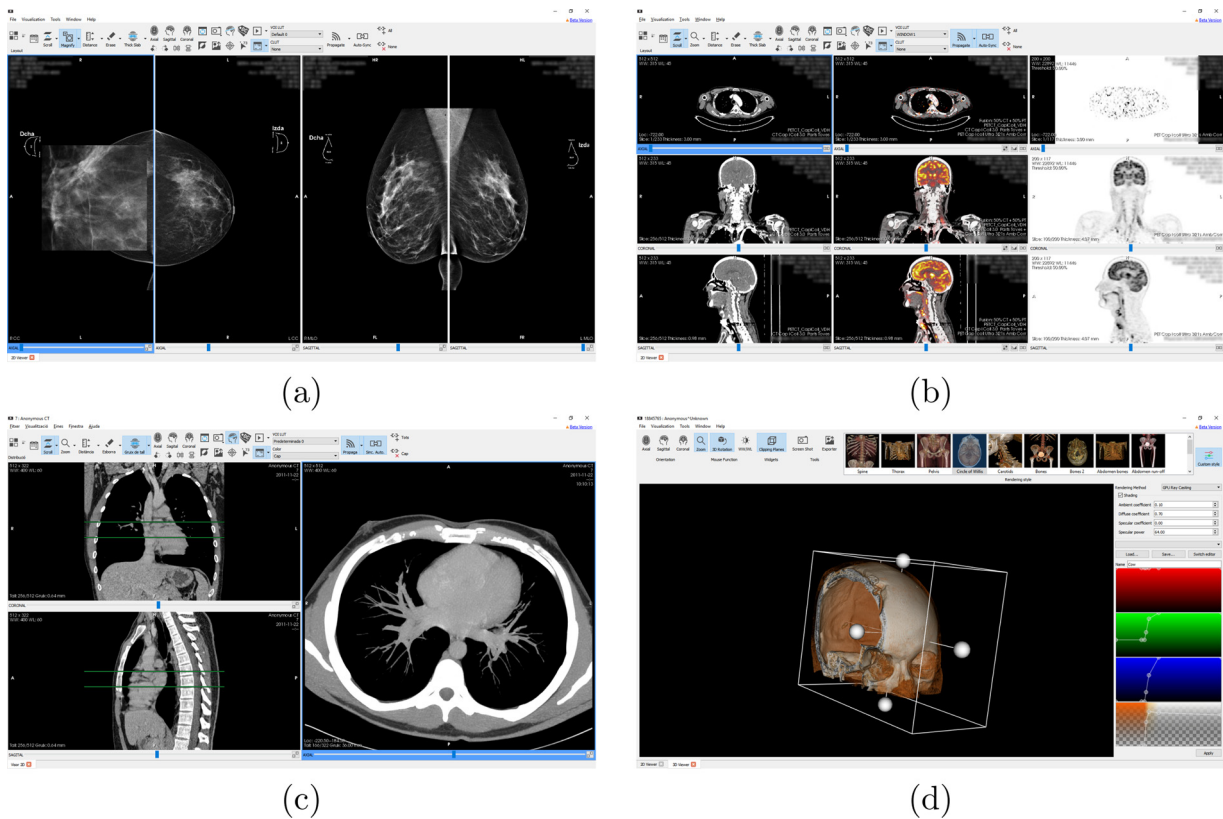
Screenshots showing several features of Starviewer. (a) 2D viewer with the magnifying glass tool. (b) 2D viewer visualizing a PET-CT with axial, coronal and sagittal reconstructions in the rows combined with the CT, PET-CT fusion and PET modalities in the columns. (c) 2D viewer showing the reference lines tool with thick slab enabled; the green lines in the coronal and sagittal viewers show the location of the axial view and its thickness. (d) 3D viewer with clipping planes enabled and a sidebar to modify the current transfer function and illumination parameters. (For interpretation of the references to color in this figure legend, the reader is referred to the web version of this article.)
